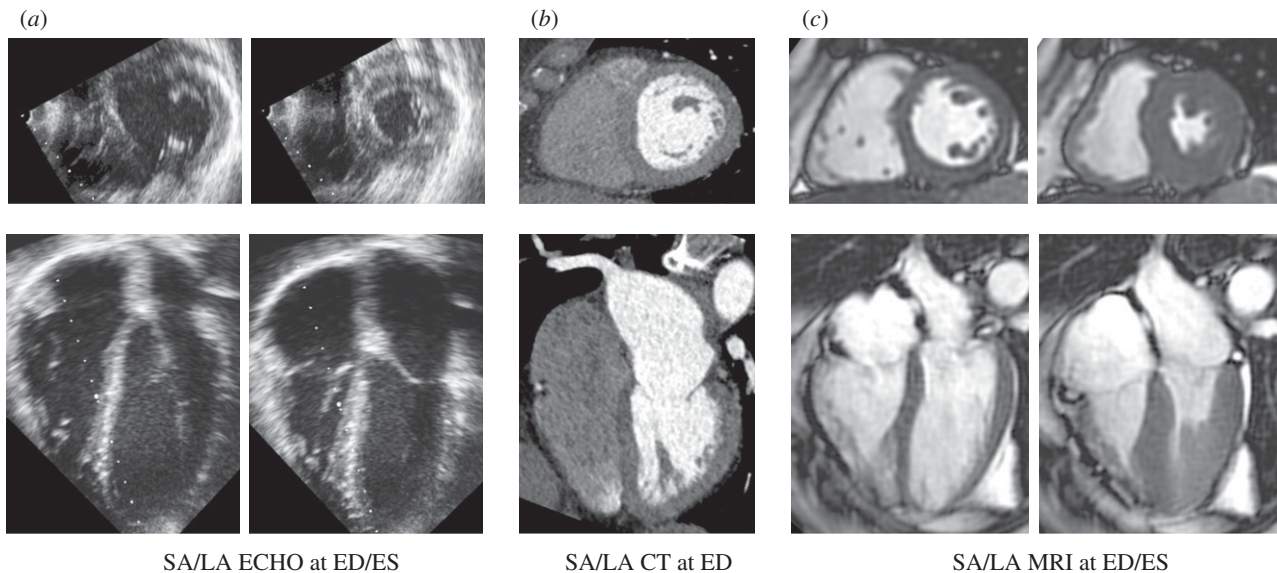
Example of typical medical images of short-axis and long-axis views of the heart. (a) ECHO images at two points in the cardiac cycle. (b) CT images at end diastole (single time point usually acquired due to radiation dose) with contrast bolus illuminating the LV blood pool. (c) CINE MRI at two points in the cardiac cycle. SA, short-axis; LA, long axis; ED, end diastole; ES, end systole.
